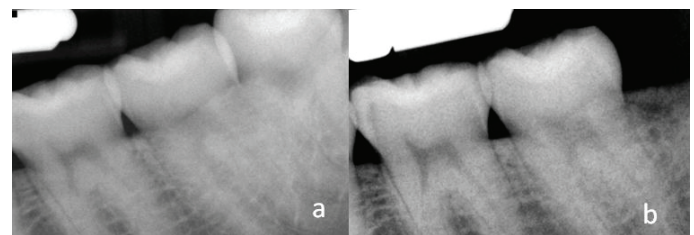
Distoangular IMP; a) Pre-operative radiograph; b) Post operative radiograph showing improved ABH at re-assessment period.
